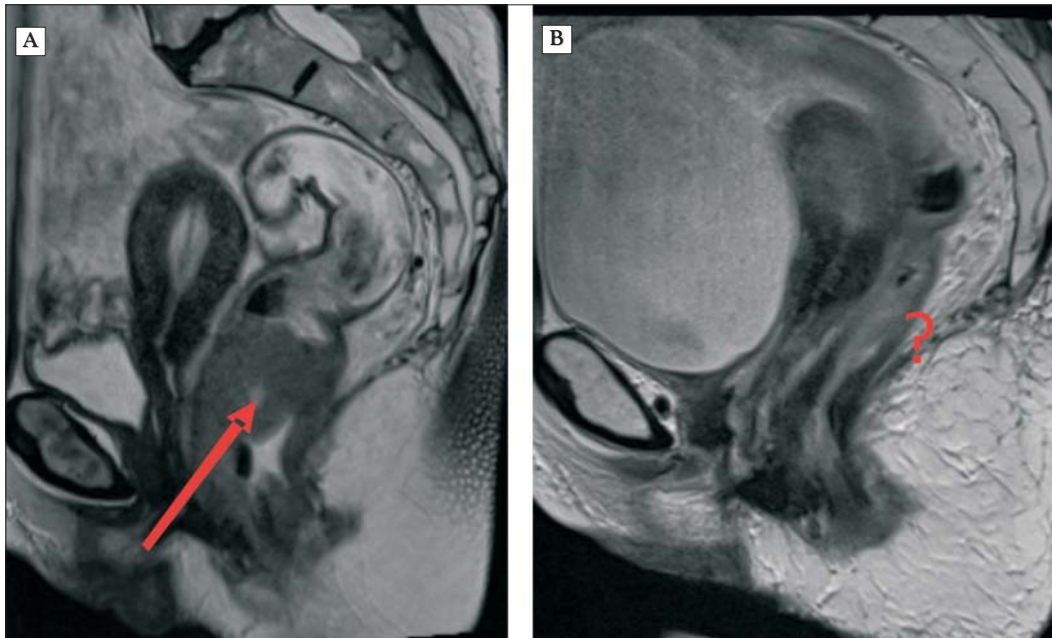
Sagittal MRI of the rectum (A) Before RCT we observe a rectal tumour (arrow), (B) after RCT the tumour is no longer visible.
